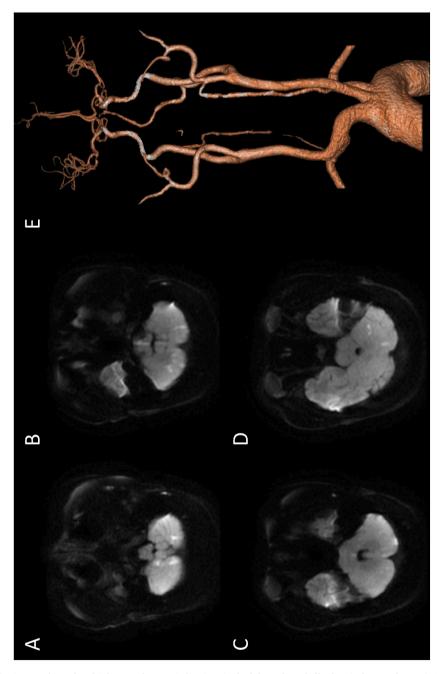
Preoperative brain MRI showed multiple acute lacunar infarctions in the bilateral cerebellar hemisphere and pons (1A and B). On the second day after the operation, brain MRI examination showed acute infarction in the bilateral cerebellar hemisphere, pons and medulla oblongata (1C and D). On the second day after the operation, head and neck CTA showed mild stenosis of the V3 segment of the left vertebral artery and severe local stenosis of the M2 segment of the right middle cerebral artery (1E).
